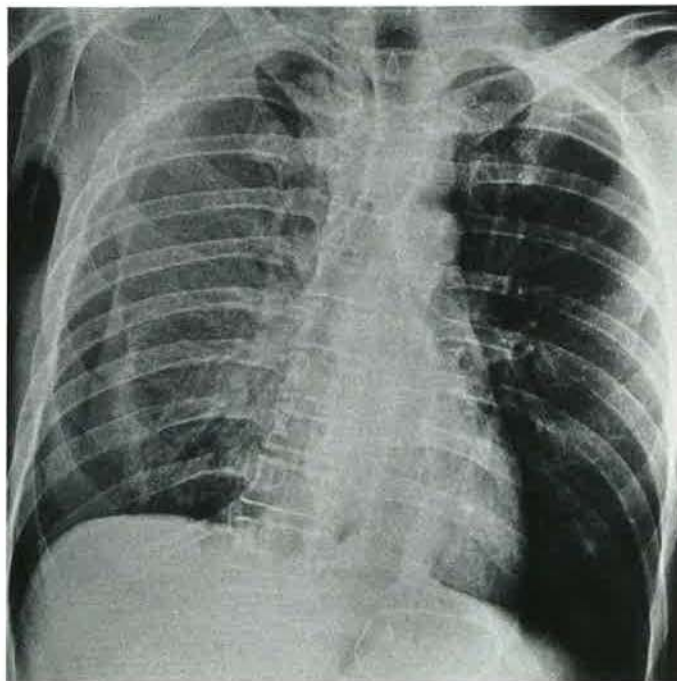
Chest X-ray in the supine position.
